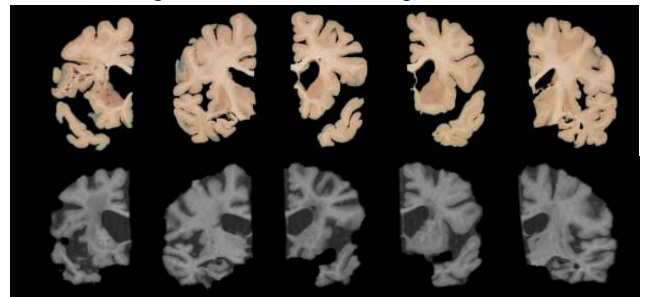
(top row) Postmortem slices (digital photographs). As an example, two slices from the left hemisphere and three slices from the right hemisphere are shown. (bottom row) Co-registered MRI slices obtained from a warping of the MRI volume.
